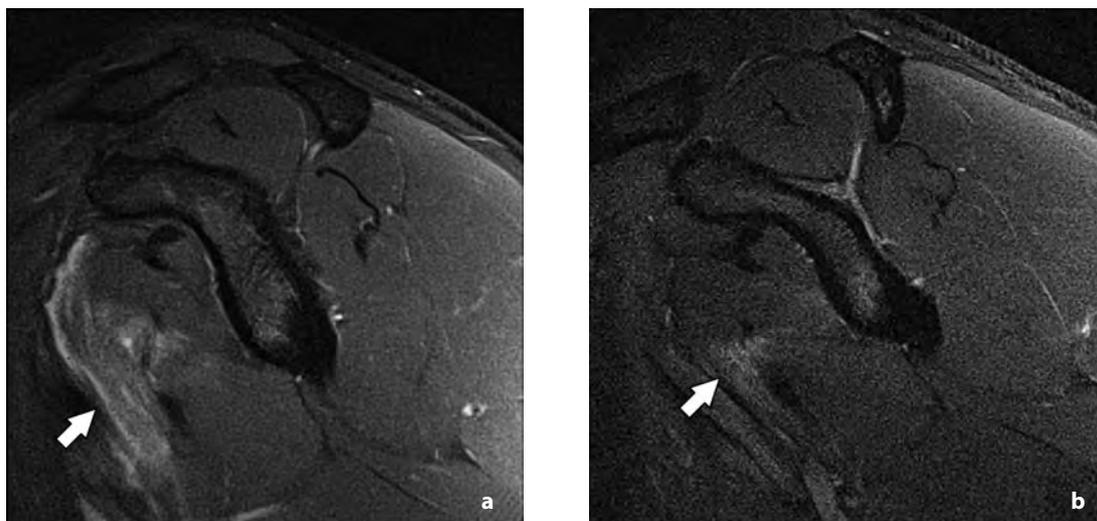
24-year-old, right hand dominant professional baseball pitcher with posterior shoulder pain after throwing a fastball: (a) Sagittal T2-weighted TSE FS MR image of the right shoulder shows a focal partial tear of the inferior subscapularis musculotendinous junction (arrow) and additional fluid tracking along the anterior surface of the muscle toward the axilla. Note high signal intensity in the affected region, (b) Sagittal T2-weighted TSE FS image of the same shoulder from a follow-up MRI 6 weeks after starting a course of conservative treatment, showed improvement in the inferior musculotendinous junction (arrow), consistent with resolving injury. Note decreased high signal intensity in the affected region.
